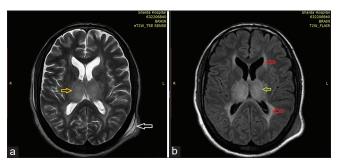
Magnetic resonance imaging axial T2W image (a) shows evidence of hypointense signal in the bilateral thalami (marked with yellow arrow) and axial fluid-attenuated inversion recovery image (b) shows the hyperintense signal in bilateral thalami (green arrow) and in periventricular deep white matter regions (marked with red arrows). The scalp edema is evident in both images shown with white arrow on image (a)
